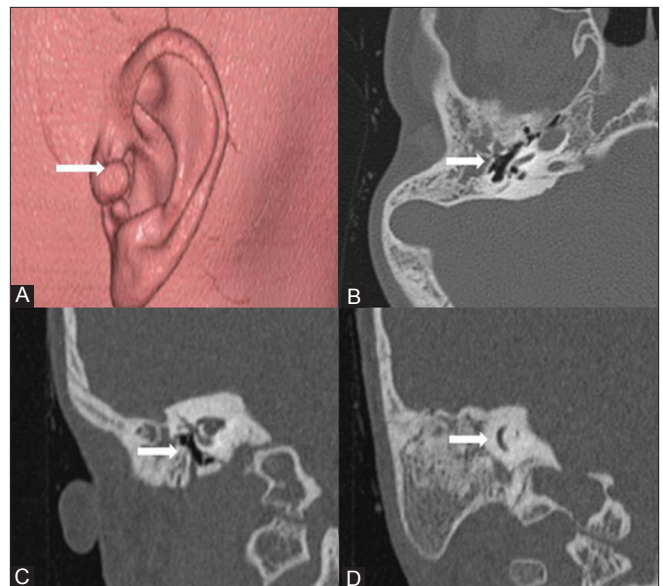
(A-D): A 17-year-old male with grade I microtia on the right side. (A) Volume rendered image shows grade I microtia. There is preservation of helix with preauricular tag (arrow). (B) Axial HRCT section shows small capacity middle ear with dysplastic ossicles (arrow). (C) Coronal HRCT section of same patient shows similar findings (arrow). (D) Coronal HRCT section also depicts non-pneumatized atretic plate with normal inner ear (arrow)
